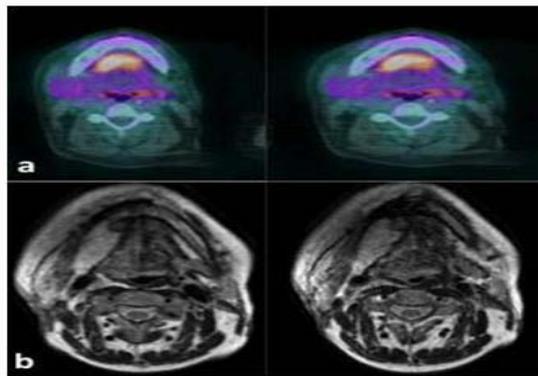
A) Pre-operative PET-CT axial scan; B) Post-operative MRI axial sc.
